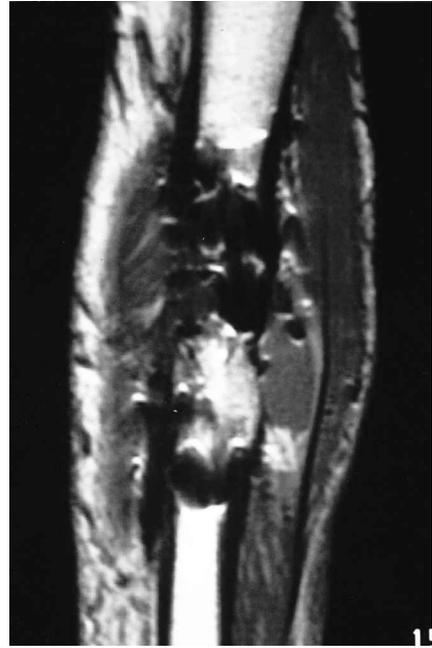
MRI shows a soft-tissue tumor in contact with the skin. Bone signal is altered because of postoperative changes.
